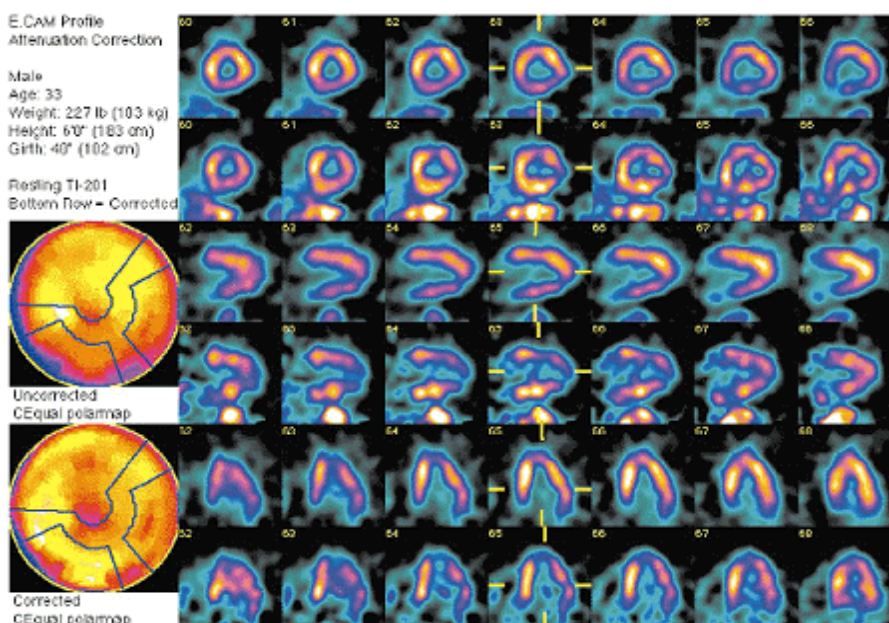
Use of the attenuation correction in myocardial SPECT with Tl-201. Row 1, 3 and 5: uncorrected, row 2, 4 and 6: attenuation corrected. Lower left: comparison of polar maps. (Siemens ICON software).
